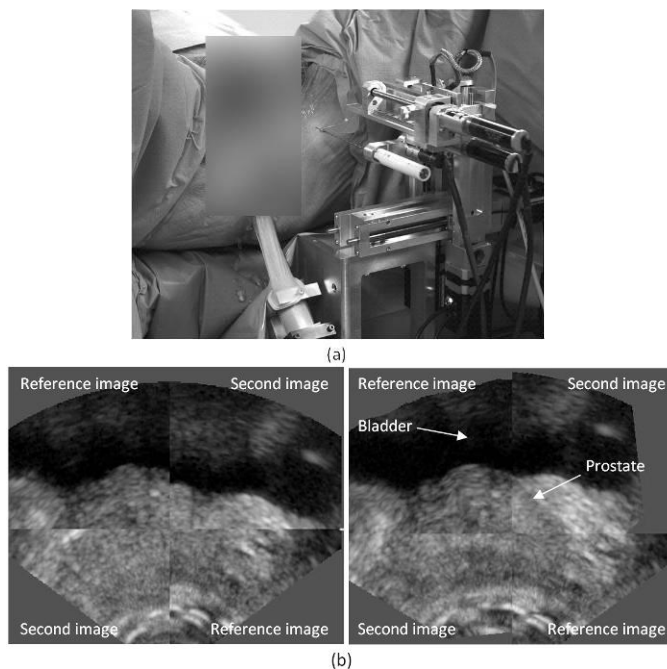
(a) The prototype PROSPER system in place during the cadaver study. (b) Transverse view of two ultrasound volumes overlain on top of each other before registration (left image) and after registration (right image).
